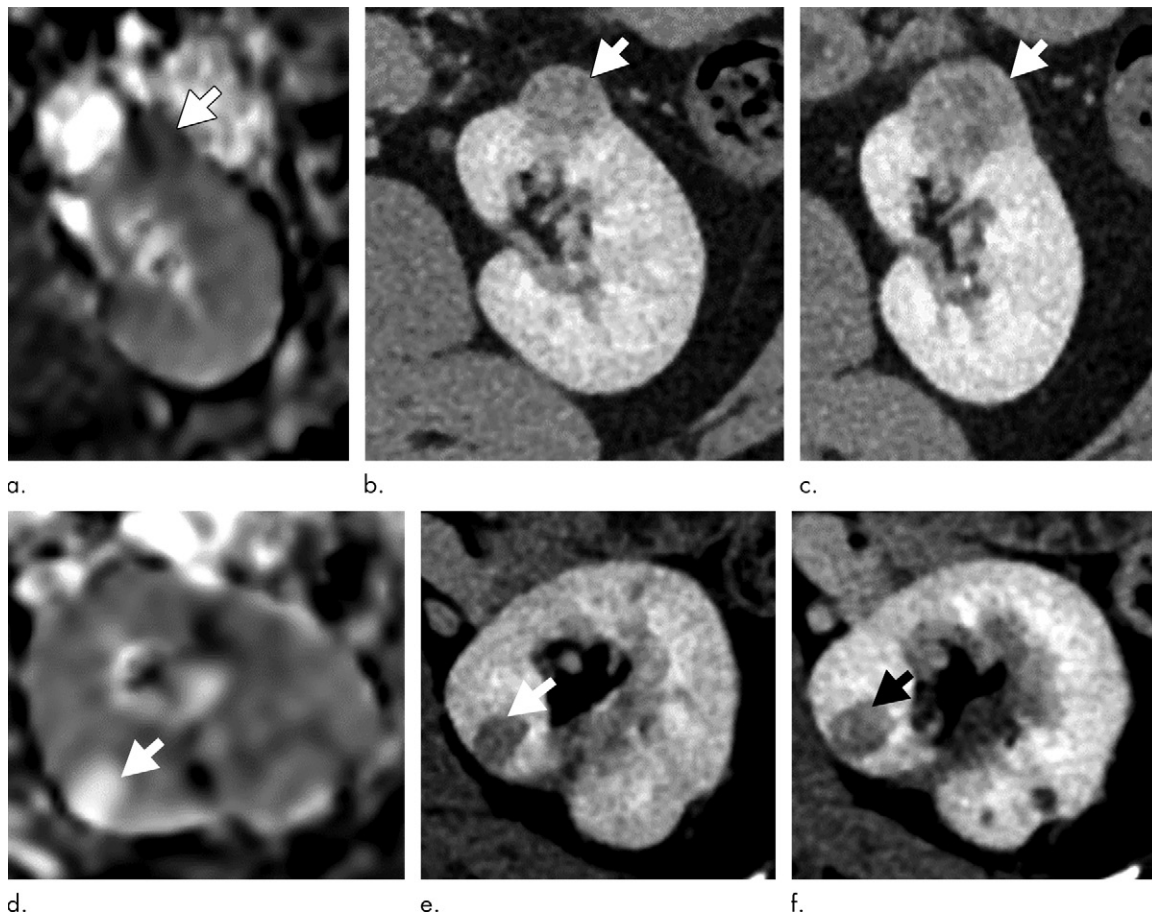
(a–c) Clear cell renal cell carcinoma (ccRCC) (arrow) in a 57-year-old man with Von Hippel–Lindau (VHL) disease that appears hypointense on (a) the baseline apparent diffusion coefficient (ADC) image (mean, $1536 \times 10^{-6} \text{ mm}^2/\text{sec}$) and shows 8.9 cm^3 per year growth and 232-day doubling time between (b) baseline and (c) follow-up contrast-enhanced CT. (d–f) ccRCC (arrow) in a 61-year-old woman with VHL disease with a hyperintense appearance on (d) the baseline ADC image (mean, $2431 \times 10^{-6} \text{ mm}^2/\text{sec}$) with 2.5-cm^3 per year growth and 1008-day doubling time between (e) baseline and (f) follow-up contrast-enhanced CT.
